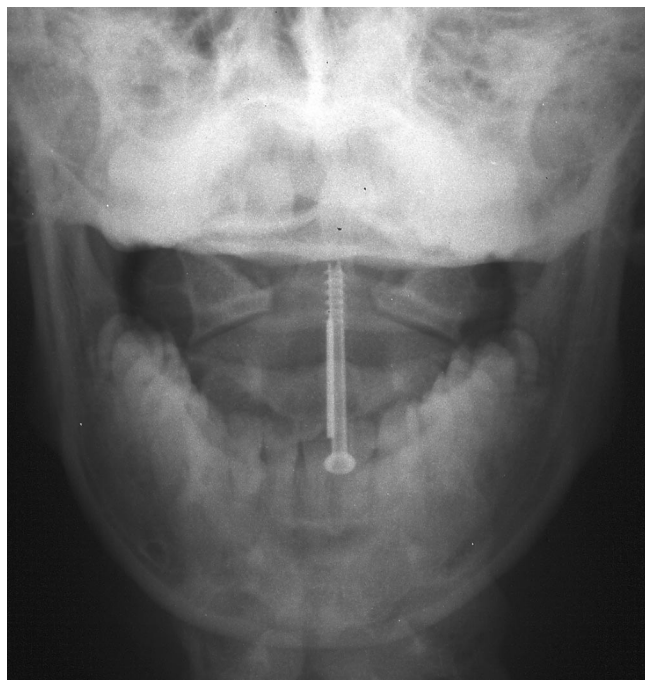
Postoperative anterior/posterior C-spine radiograph showing the implanted screw and the broken K-wire fragment.
